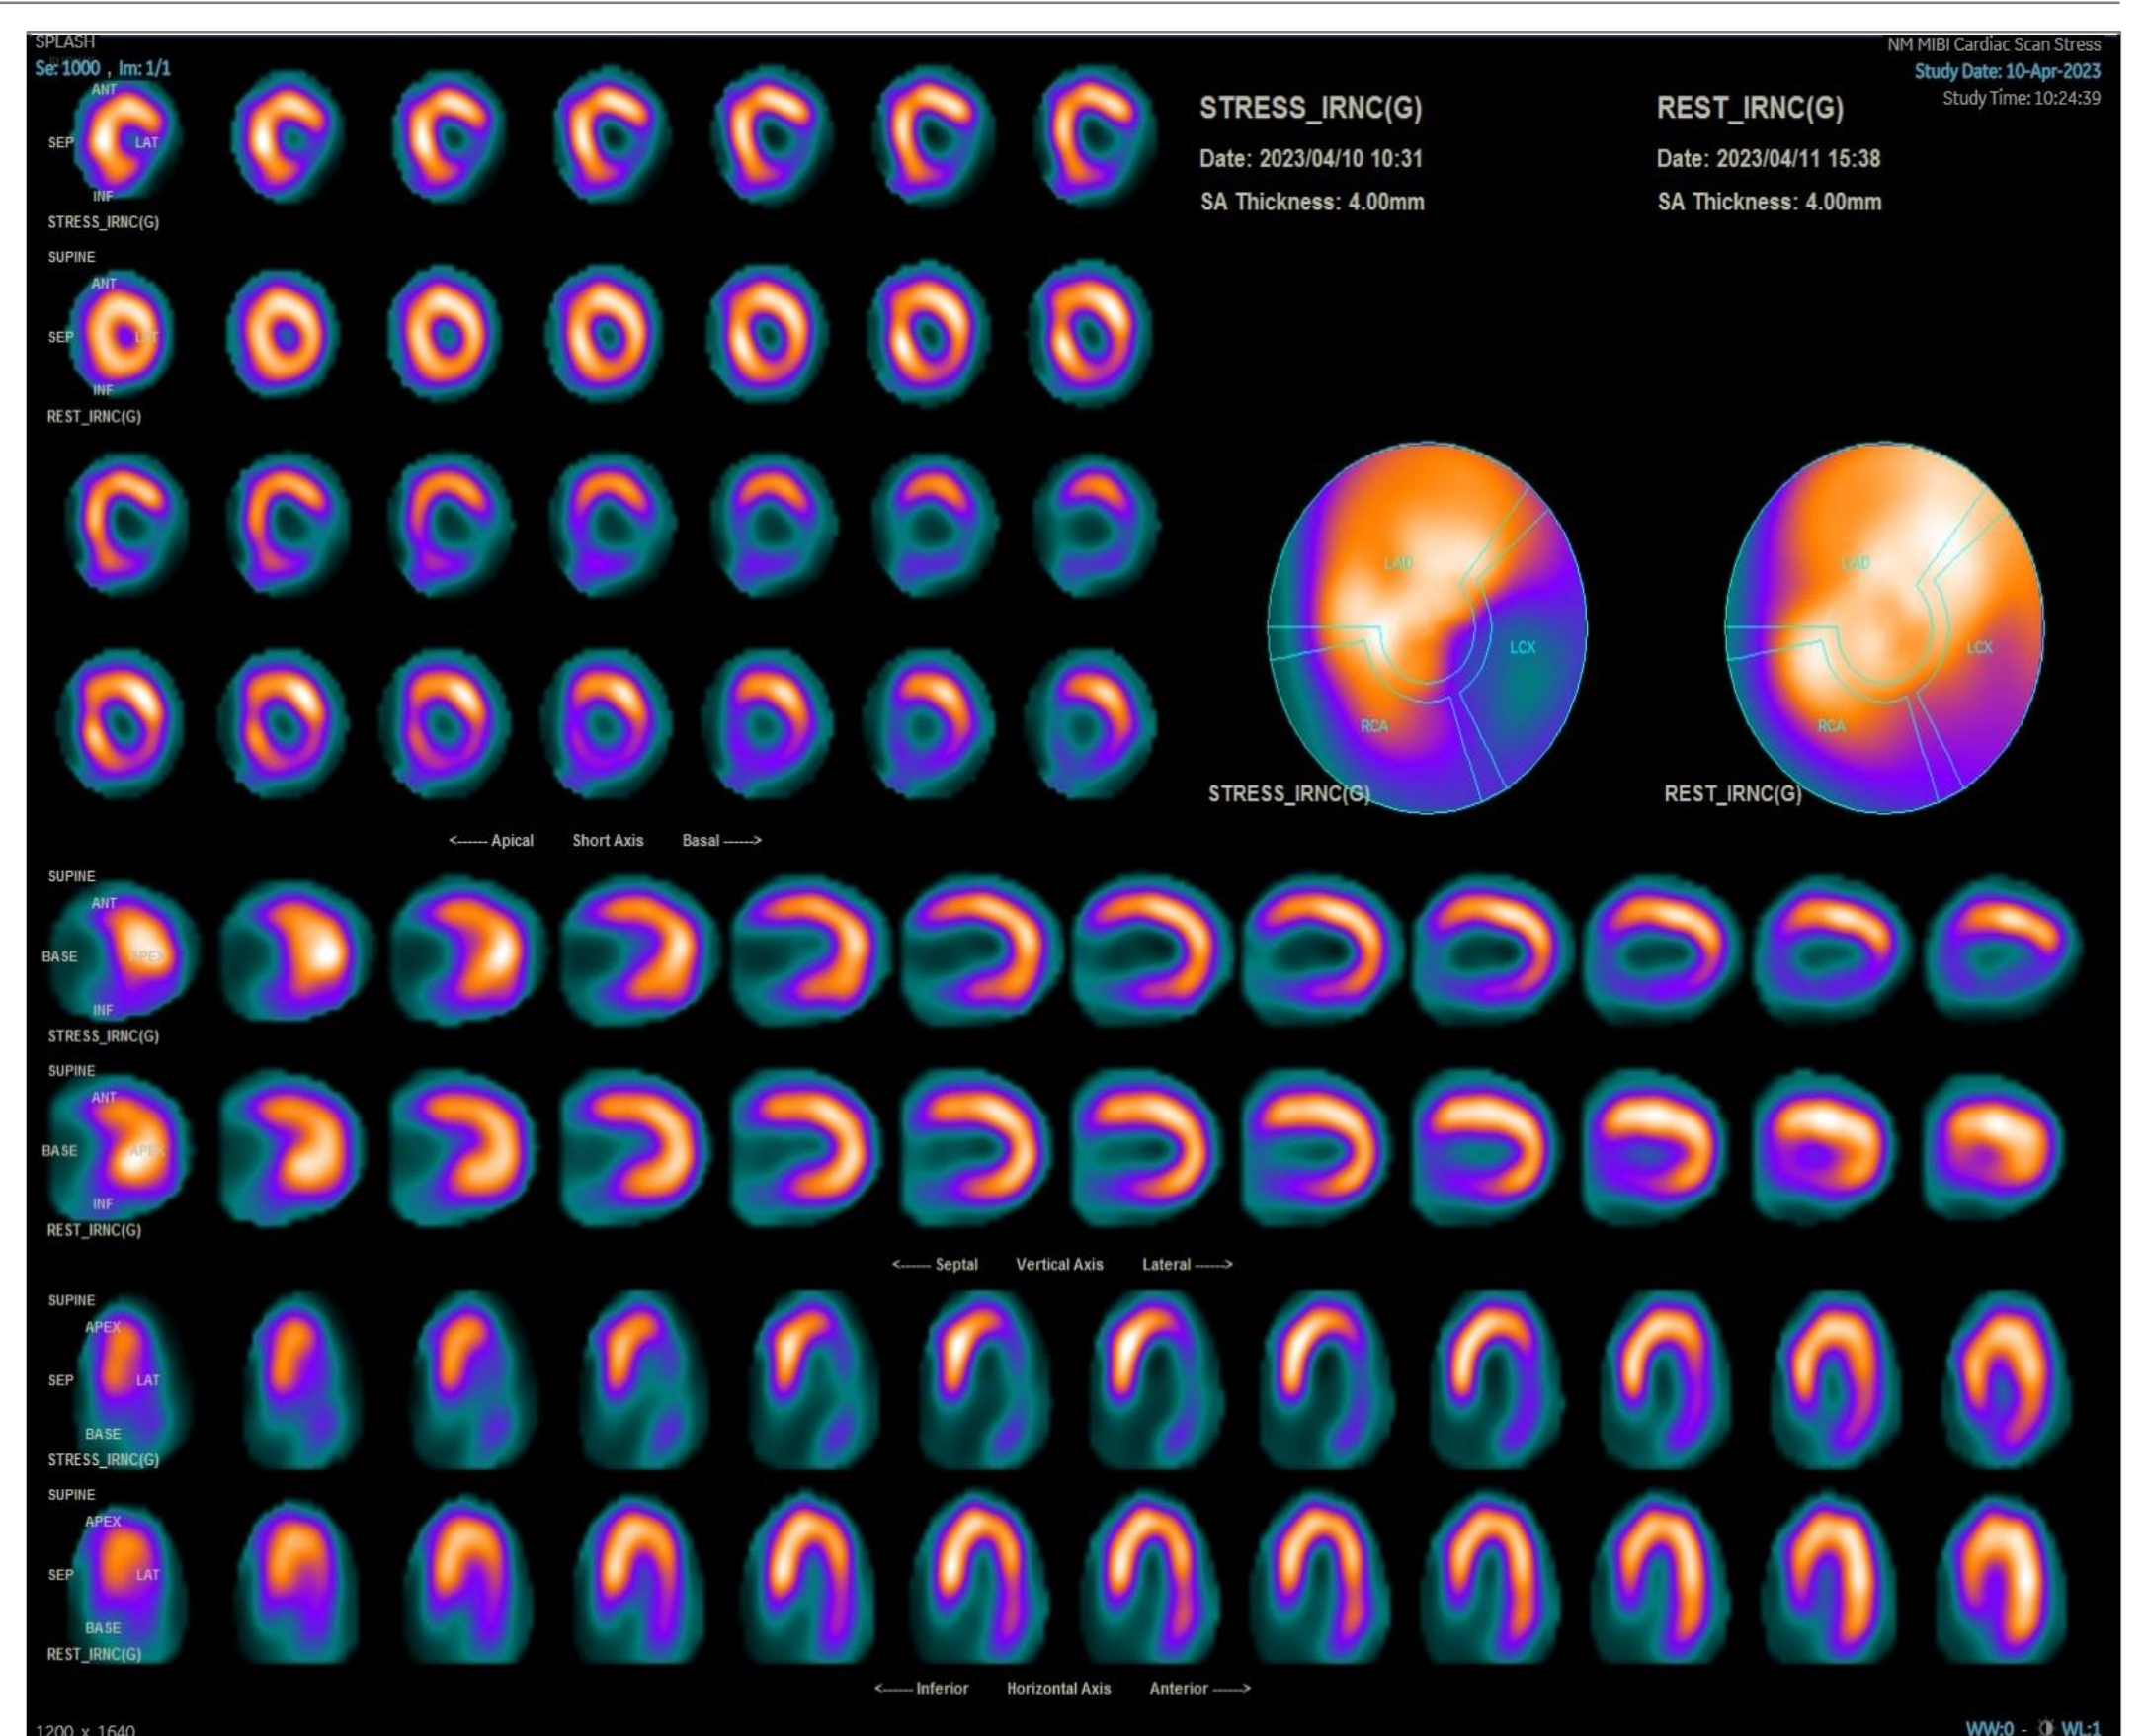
Stress-Rest MIBI SPECT images showing perfusion defects in the inferolateral segment
